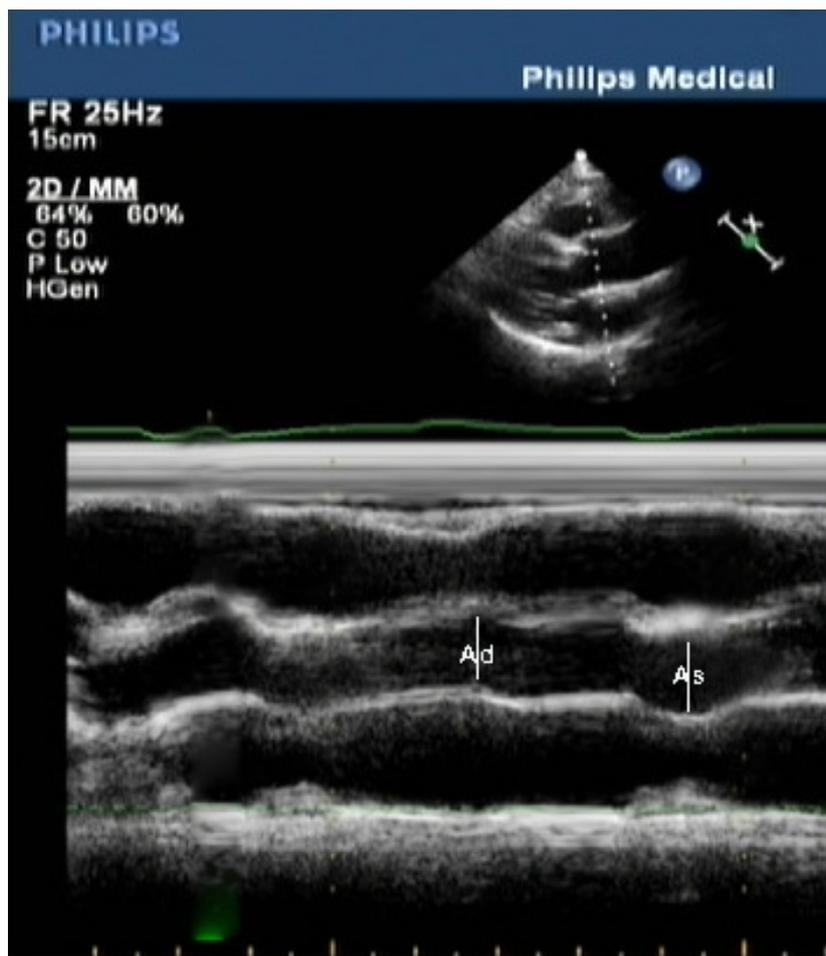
M-mode echocardiography recordings of the ascending aorta in parasternal long-axis view showing the measurement of systolic aortic diameter (As), and diastolic aortic diameter (Ad). The measurements were made at the same point at a level 3 cm above the aortic cusps.
